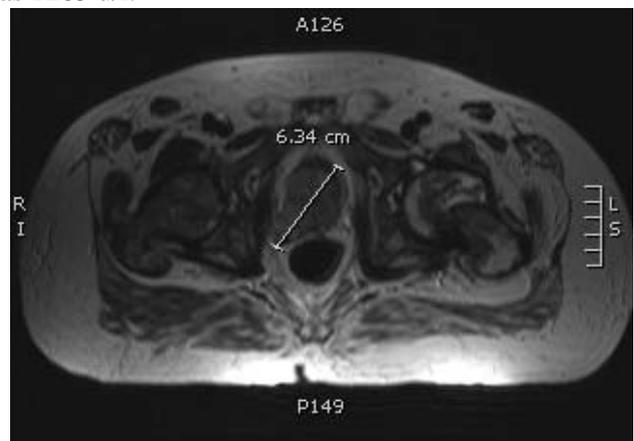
axial MRI T2WI: heterogeneous prostatic mass.
